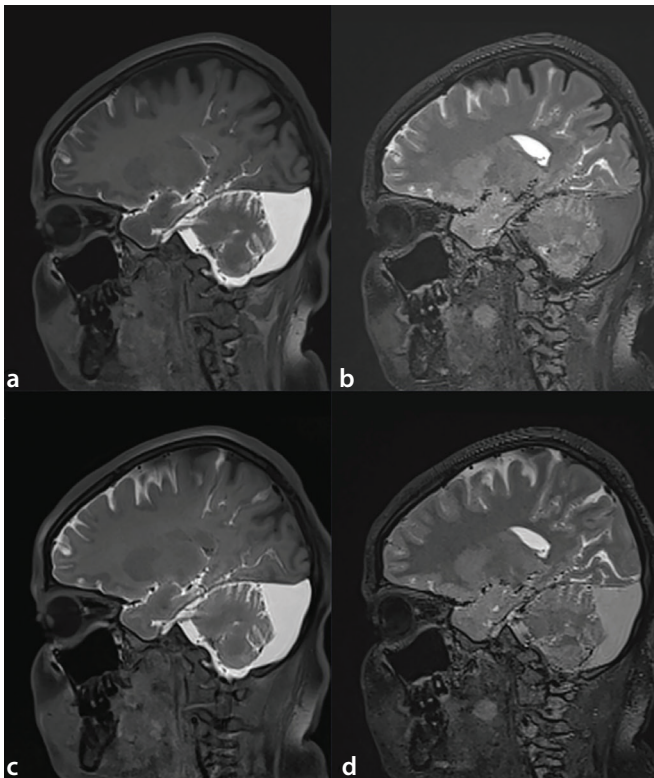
Example of a retrocerebellar CC-AC. The EP-T1 image (a) shows near-complete opacification (grade 4). The EP-FLAIR image (b) shows mild partial opacification (grade 2). The LP-T1 image (c) shows near-complete opacification (grade 4). The LP-FLAIR image (d) shows moderate opacification involving most of the cyst (grade 3). AC, arachnoid cyst; CC, completely communicating; EP, early phase; EP, early phase; FLAIR, fluid-attenuated inversion recovery; LP, late phase.
